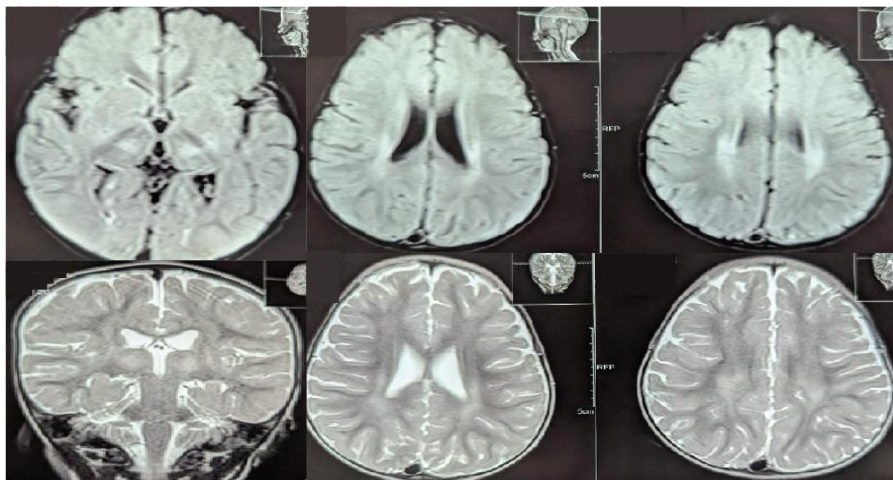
Bilateral symmetrical T2WI/FLAIR hyperintense signal changes at corona radiata, centrum semiovale and thalamus of both cerebral hemispheres.
